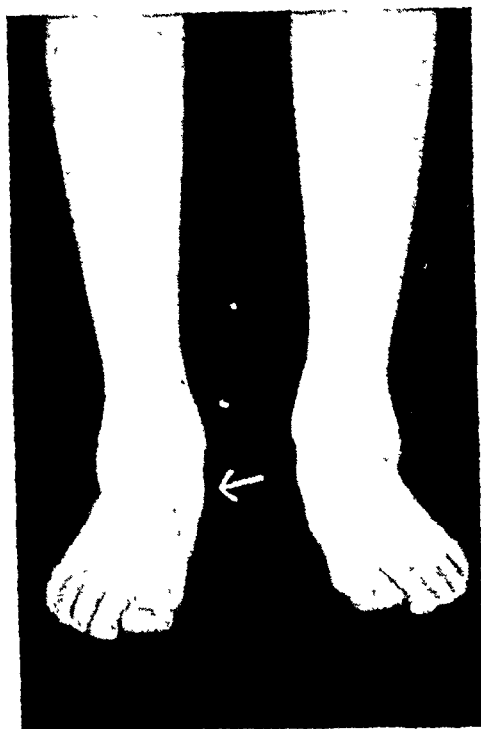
Prehallux or accessory scaphoid. A (left), patient showing marked pronation and prominence of the scaphoid bones, B (right), dorsoplantar roentgenogram showing accessory scaphoid
